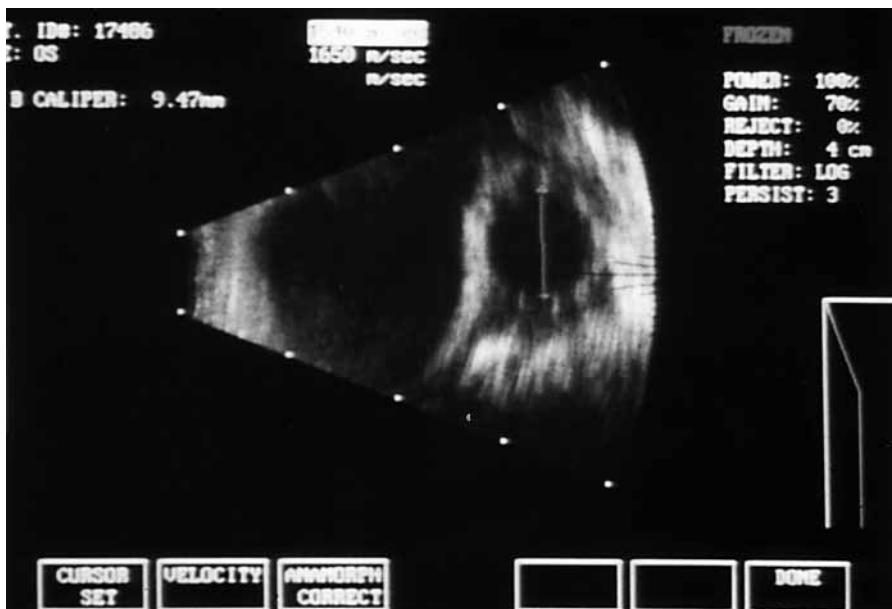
An ultrasonogram to confirm the position of the balloon. The diameter of the balloon (vertical line) is 9.47 mm.
